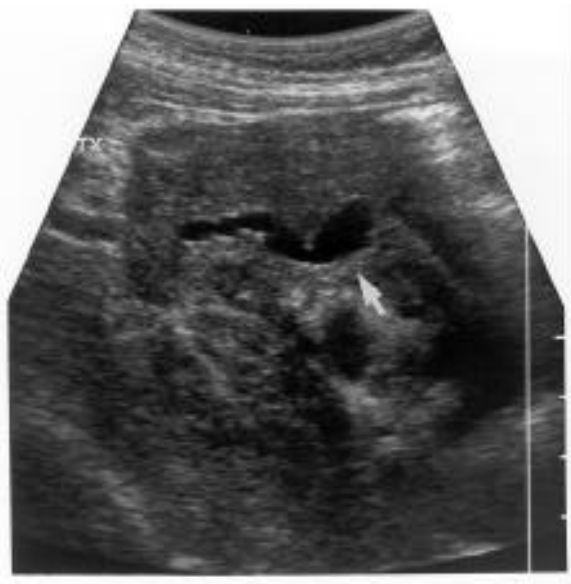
Ultrasound evaluation showed the pancreas transplanted in the right iliac fossa. A tubular structure was identified within the transplanted pancreas, which likely represented a dilated pancreatic duct. This structure measured 10.3 mm in transverse dimension.
